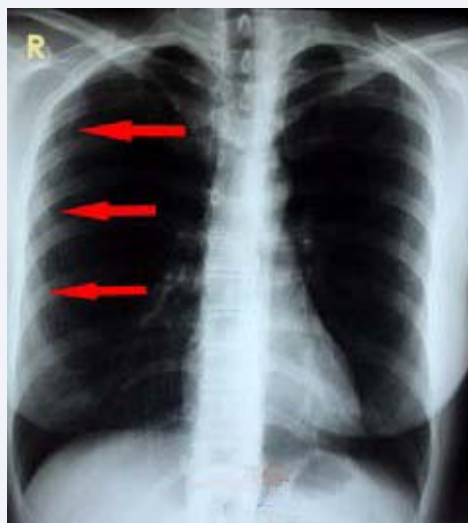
X-ray photo of right-sided pneumothorax, about 2cm.
